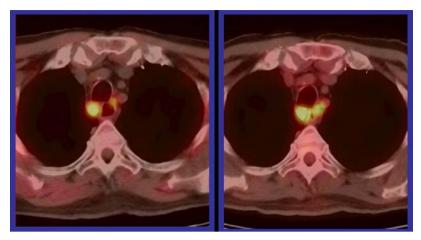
FDG uptake in mediastinal lymphadenopathy in a patient with lymphoma. Left: Image obtained with the patient in a hyperglycaemic state. Right: Images obtained 2 days later of the same patient in the normal glycaemic state. Note how the same lymph nodes exhibited increased uptake after proper patient preparation.
